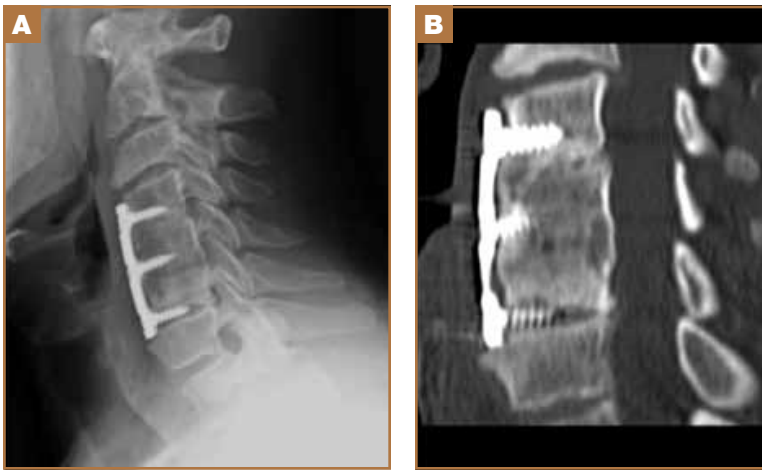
(A) Lateral radiograph and (B) sagittal CT image show osseous union at C4-C5 and C5-C6 with screw migration into the C6-C7 intervertebral disc space.
